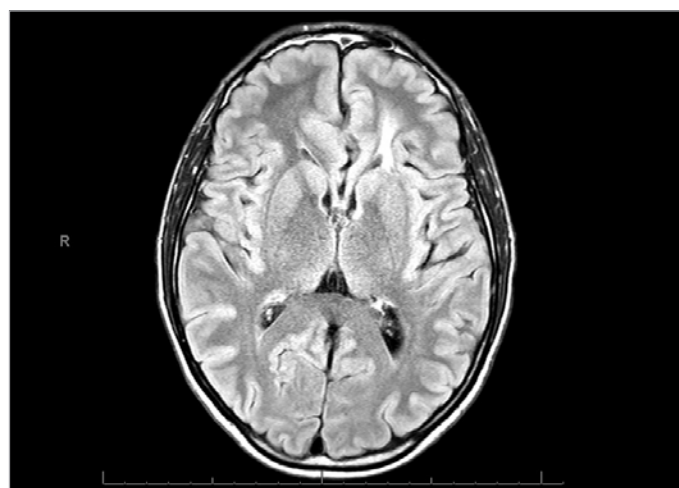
Brain magnetic resonance imaging with sequelae of radiosurgery.
